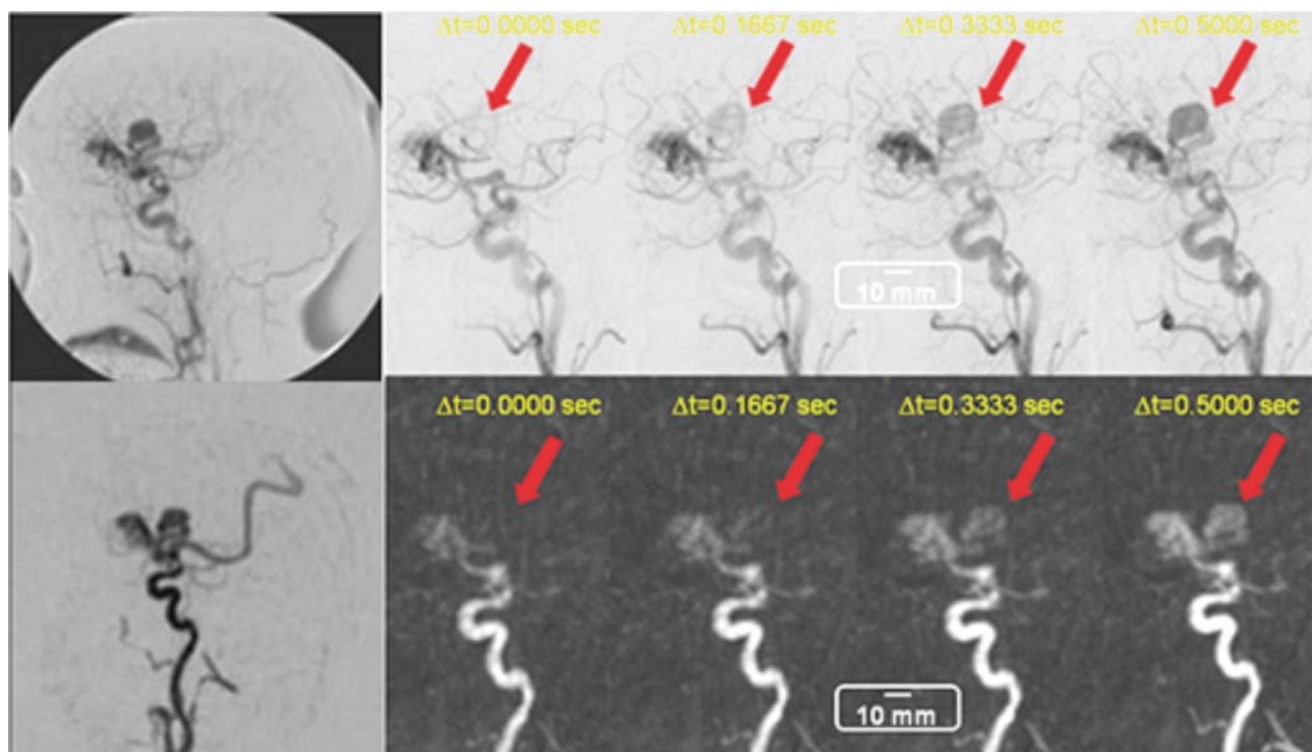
Intracranial arteriovenous malformation visualized with both 2D X-Ray DSA (*top*) and radial stack of stars CE-MRA with sliding window reconstruction (*bottom*). The use of radial stack of stars sampling and sliding window reconstruction allows identical frame rates between
